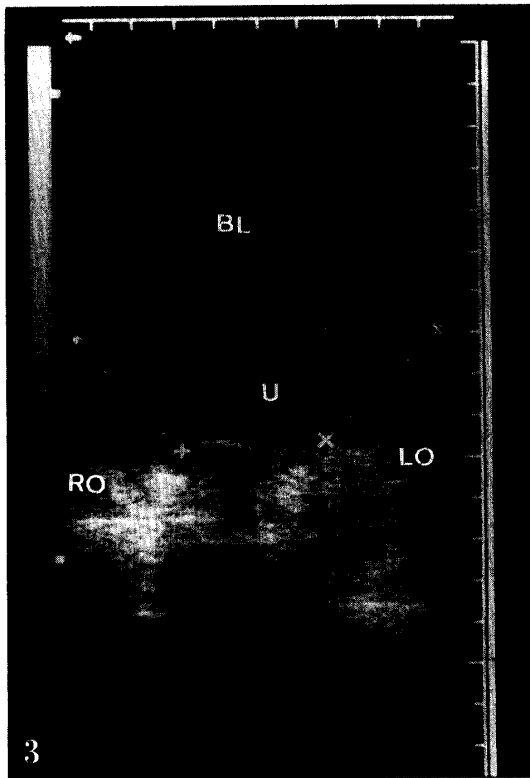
Ultrasonogram of peripheral cystic ovary (LO; left ovary) and dominant single cystic ovary (RO; right ovary) in Case 6. BL; bladder, U; uterus.
